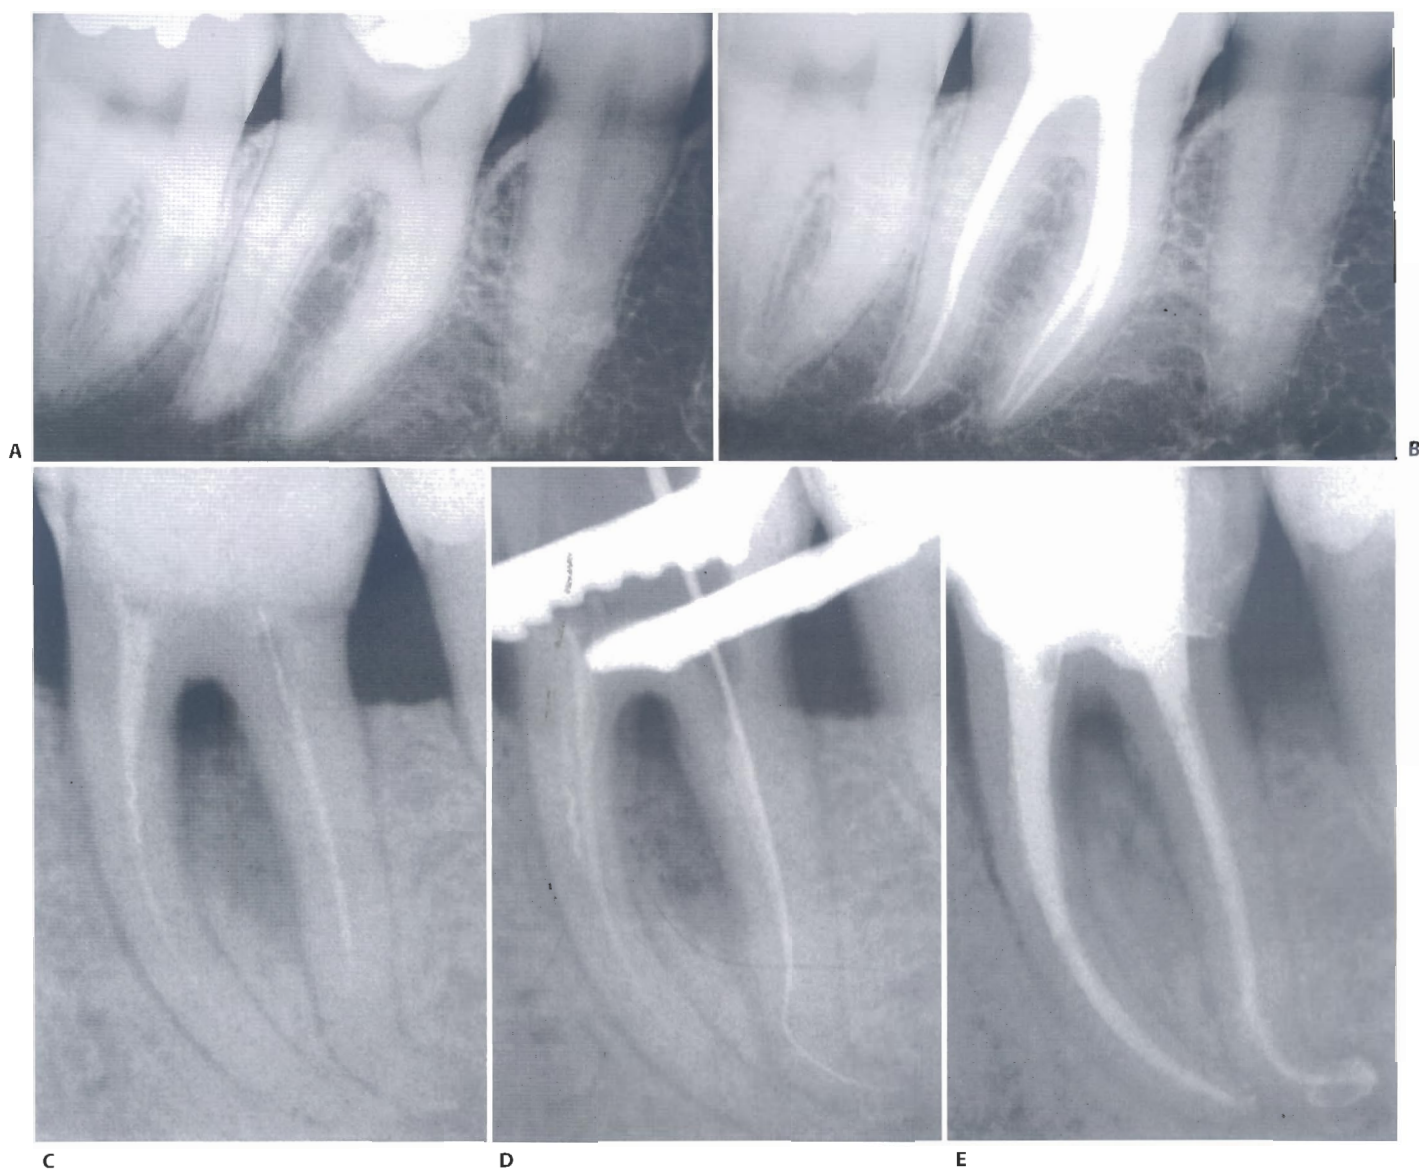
Clinical cases of teeth with calcified canals where the preshaping with hand files is very important. A. Preoperative radiograph of the lower right first molar. B. Postoperative radiograph (E. Berutti). C. Preoperative radiograph of lower left first molar. D. Radiograph to check the working length of the distal canal. E. Postoperative radiograph (G. Cantatore).
